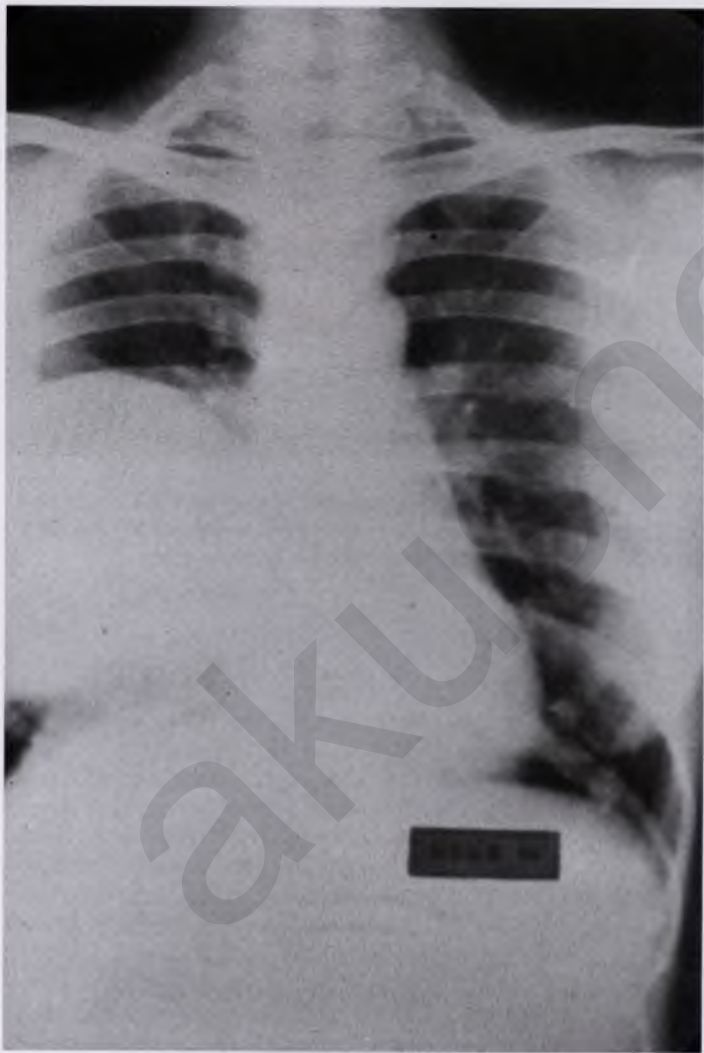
The most common metastatic site associated with choriocarcinoma is the lung. This radiograph shows a large, cannonball lesion occupying the greater part of the right lung.
